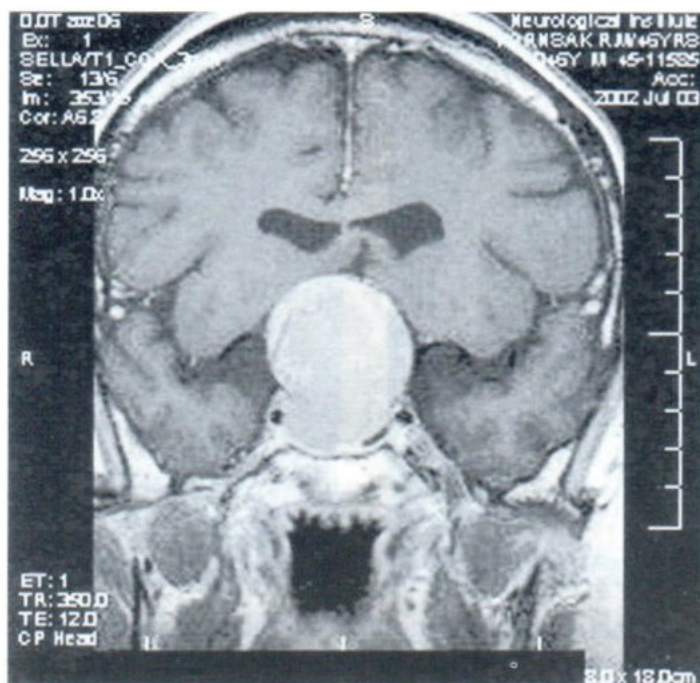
MRI coronal T1W (TR/TE 350/12) scan following intravenous gadolinium injection shows rather heterogeneously and moderately enhancement of the tumor mass.
